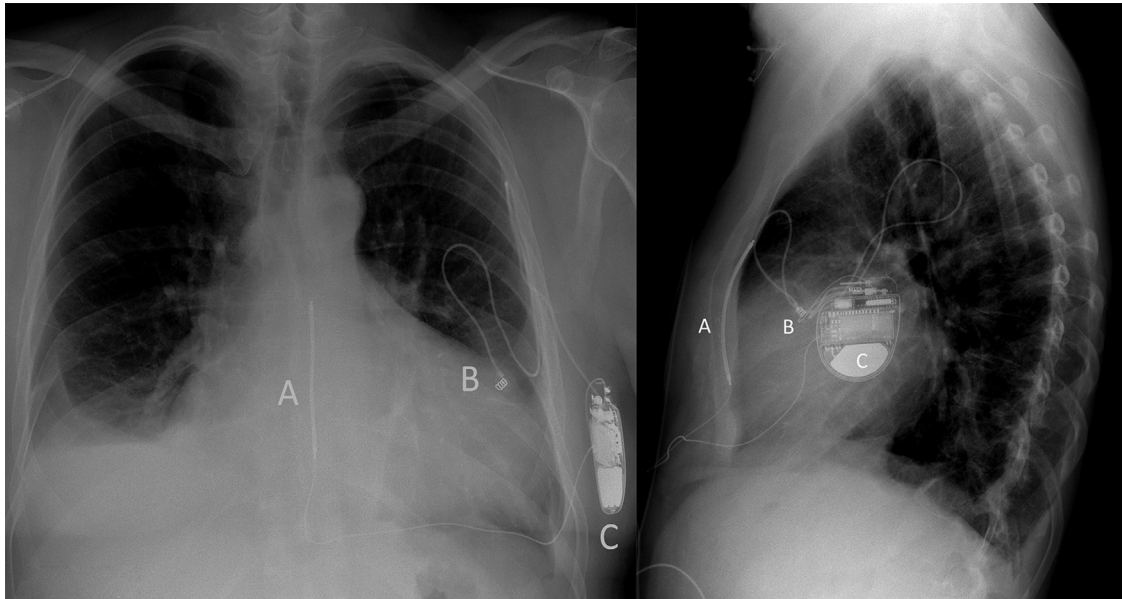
Chest radiograph 3 months after implantation in anteroposterior and left lateral projection. A: Substernal implantable cardioverter-defibrillator (ICD) lead. B: Epicardial pace/sense electrode. C: Left lateral midaxillary-placed conventional ICD can.
